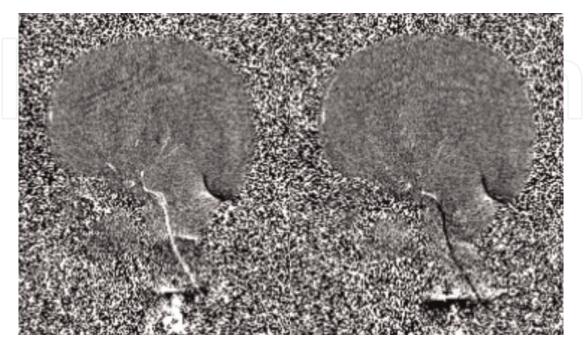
The cine-phase MRI examination of flow of cerebrospinal fluid through endoscopic third ventriculostomy in the child with hydrocephalus.
